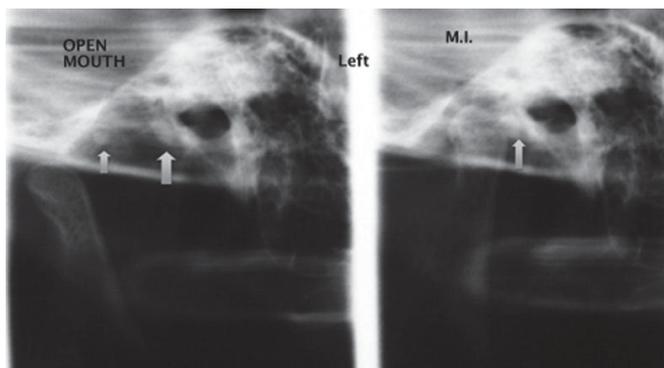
Case 1. Orthopantomograph of left TMJ: Maximum intercuspation (MI) and open mouth. Arrows point to the loose bodies.
